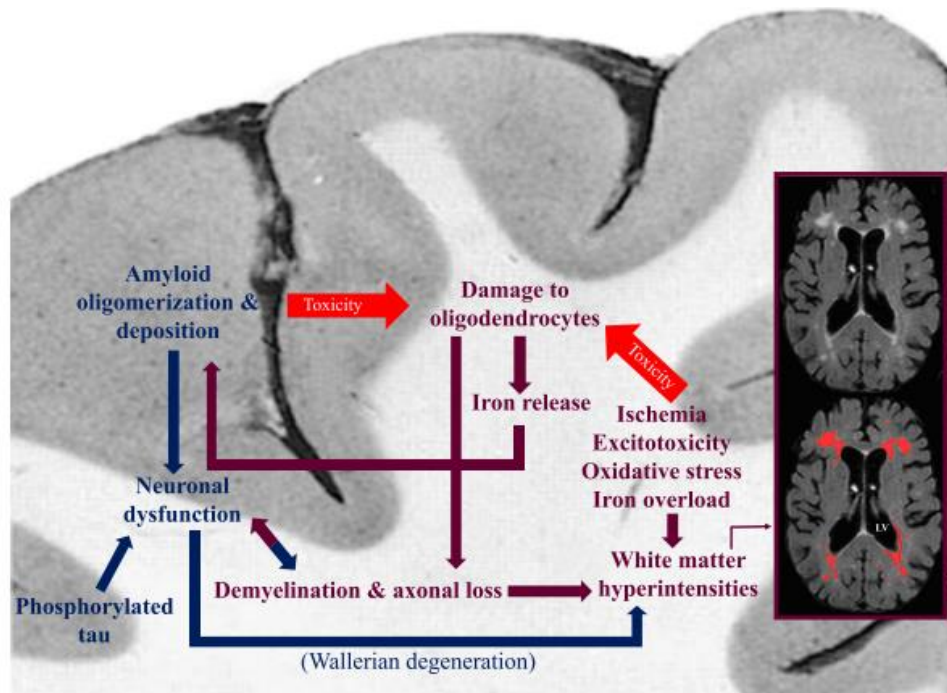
This figure summarizes the pathological cascades, and their relation with each other, during the development of the disease in white matter and cortex. WMHs are labelled with red in the MRI (FLAIR) scan. Blue arrows: direction of the damages originating in GM. Maroon arrows: direction of the damages originating in white matter. LV: lateral ventricle levels [12].
